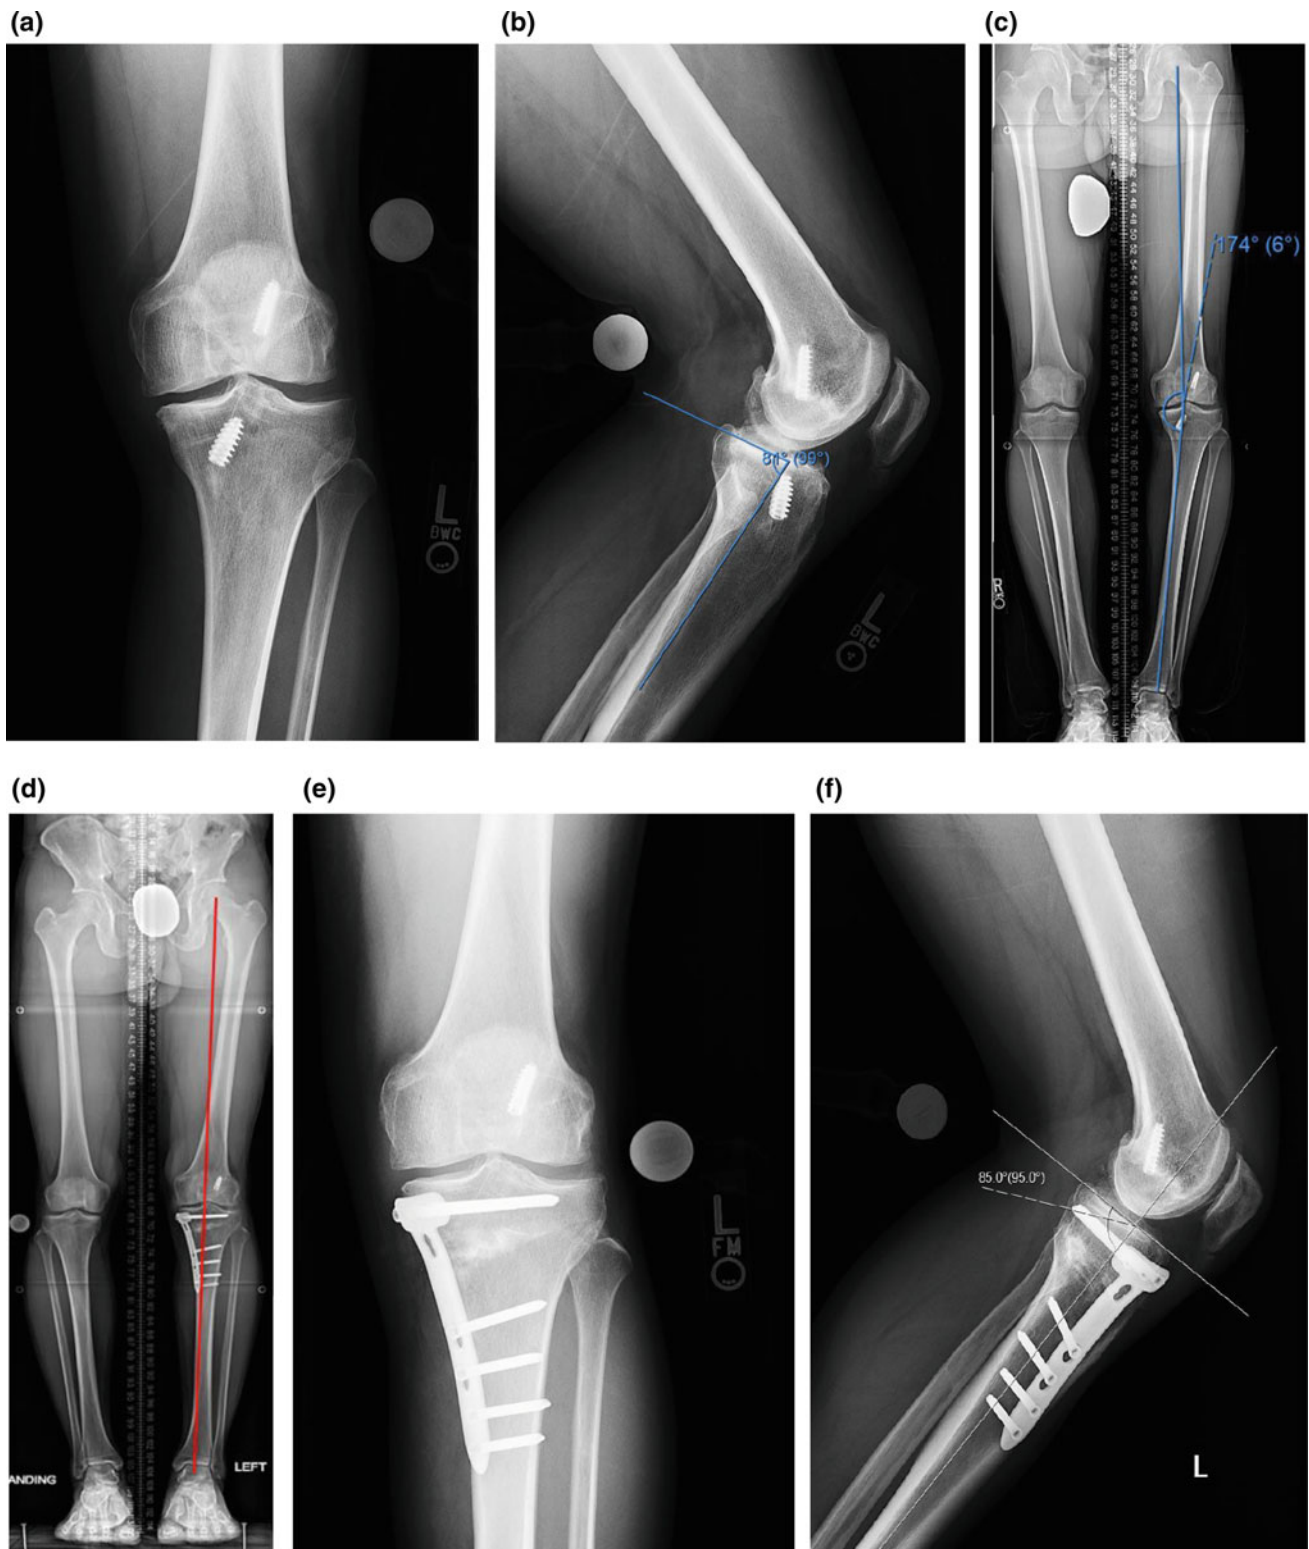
Thirty-six-year-old male with Grade 2 medial side DJD and excessive posterior slope after a failed ACL. a Pre-HTO AP radiograph left knee; b Pre-HTO lateral radiograph left knee showing a 9° tibial slope; c Pre-HTO standing bilateral radiograph HKA showing 6° varus deformity; d Post-HTO standing bilateral radiograph HKA; e Post-HTO AP radiograph left knee; f Post-HTO lateral radiograph left knee showing a 5° tibial slope
